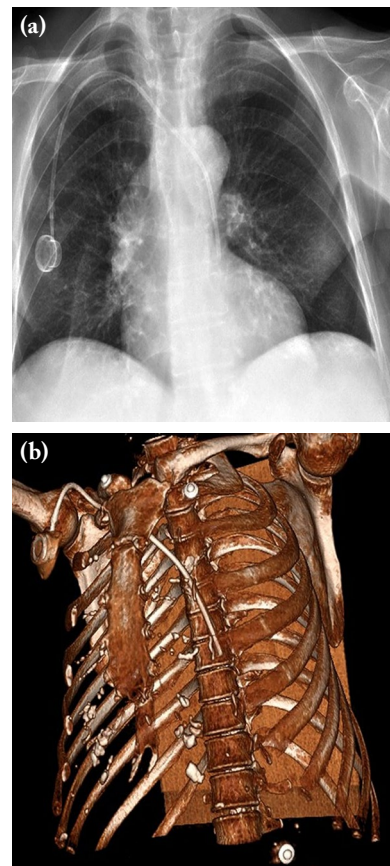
(a) Chest X-ray image. (b) Three-dimensional image showing unusual course of central venous catheter.
